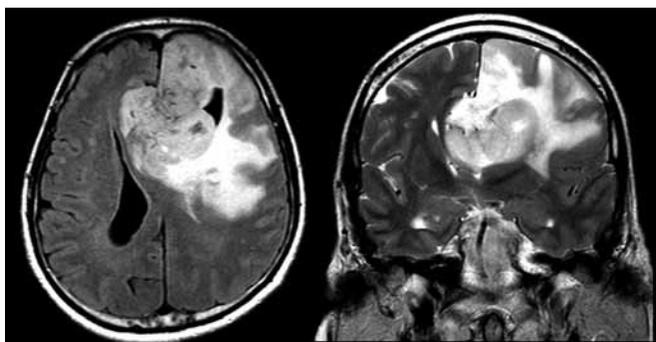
Cerebral MR with axial FLAIR sequences and T2 information. 60-year-old patient with behavioral alteration (frontal syndrome) for three months. There is a left frontal intraaxial mass, with surrounding vasogenic edema and signs of subfalcine and uncus herniation, consistent with an advanced glioma.
